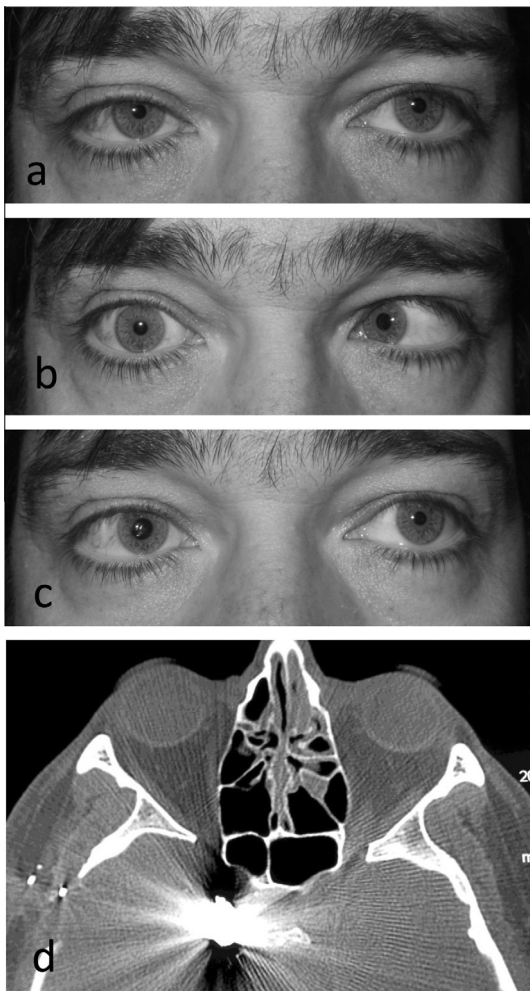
(a and b) RE VI nerve palsy and HS. (c) Apraclonidine 0.5% response after 40 min. (d) CT axial view shows a metallic foreign body at the right CS.
